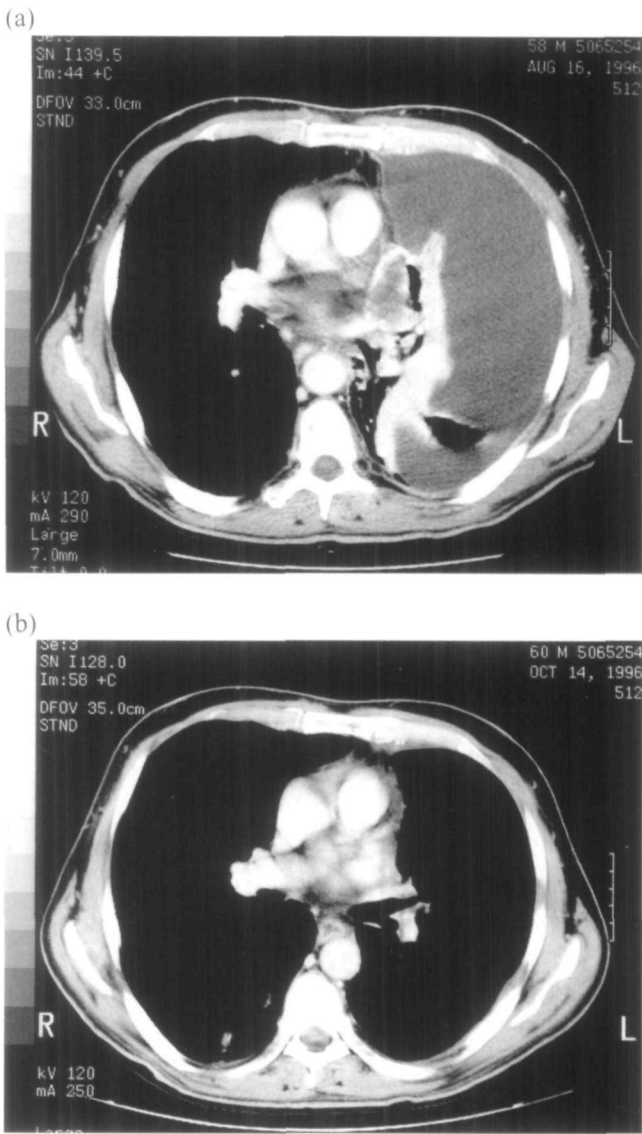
(a) CT scan of the chest at the time of presentation showing a 4.0×2.6 cm left hilar mass and a large left-sided pleural effusion; (b) a follow-up CT scan after two cycles of MAID chemotherapy showing a complete resolution of the left hilar mass and a dramatic improvement in the left-sided pleural effusion.
